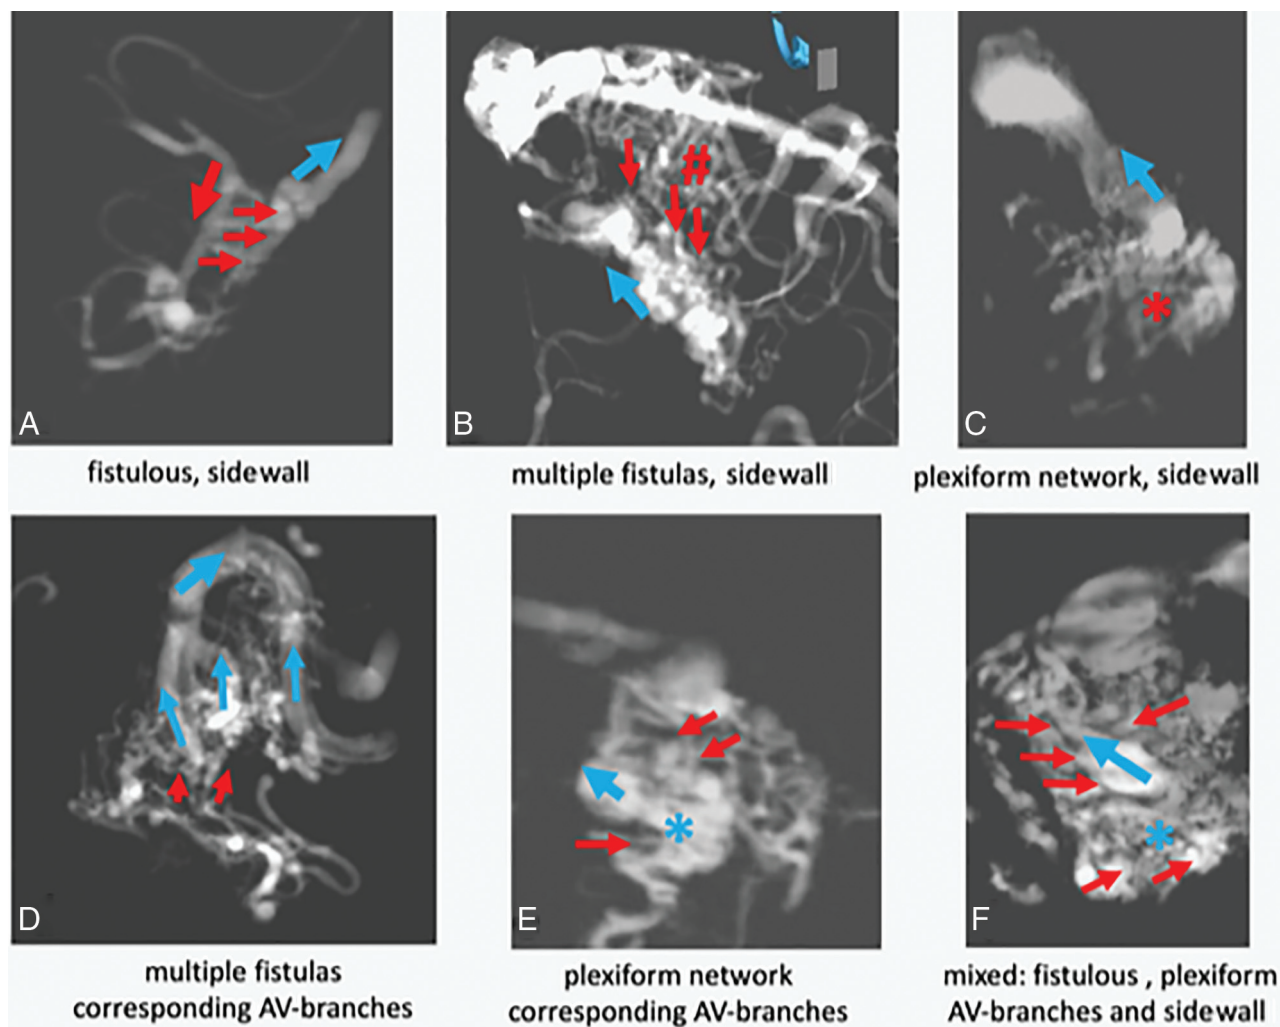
4D-fPCBCTA reconstructions of the intranidal shunt zone to demonstrate different types of transitions between arterial and venous parts of the nidus in clinical cases: *A*, small AVM with several direct fistulas (small red arrows) between the feeding artery passing the nidus (large red arrow) to the sidewall of the draining vein (blue arrow). No arterial or venous branching. *B*, Multiple direct fistulas (small red arrows) to the sidewall of the tortuous draining vein (large blue arrow). Note the perinidal connections between the feeding arteries (red hashtag) in multiple fistulas, sidewall of Fig 2*B*. *C*, A plexiform arterial network (red asterisk) before multiple small shunts to the sidewall of the draining vein (blue arrow). *D*, Multiple fistulous connections between lenticulostriate arteries and corresponding branches of the thalamostriate vein in a basal ganglia AVM. *E*, A loose network of arterial branches with transition into corresponding venous branches connected to the compartmental draining vein (blue asterisk and arrow). *F*, A mixed pattern with multiple direct fistulas to the sidewall of the draining vein in the upper part of the nidus (small red arrows). A plexiform network of arterial branches with corresponding venous branches to a venous confluence (blue asterisk) connected to the draining vein (blue arrow) in the lower part of the nidus.
